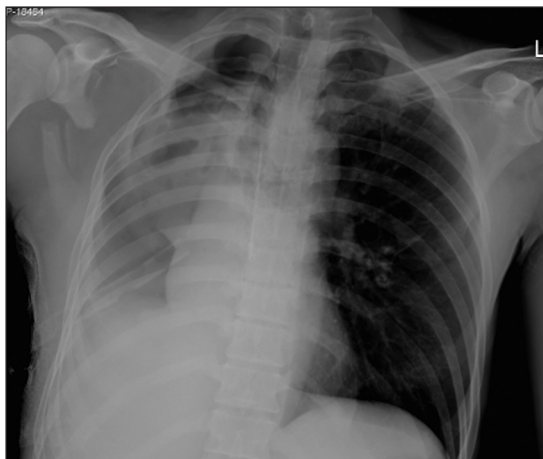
Chest X-ray showed collapsed right lung with mediastinal shift toward the right side
